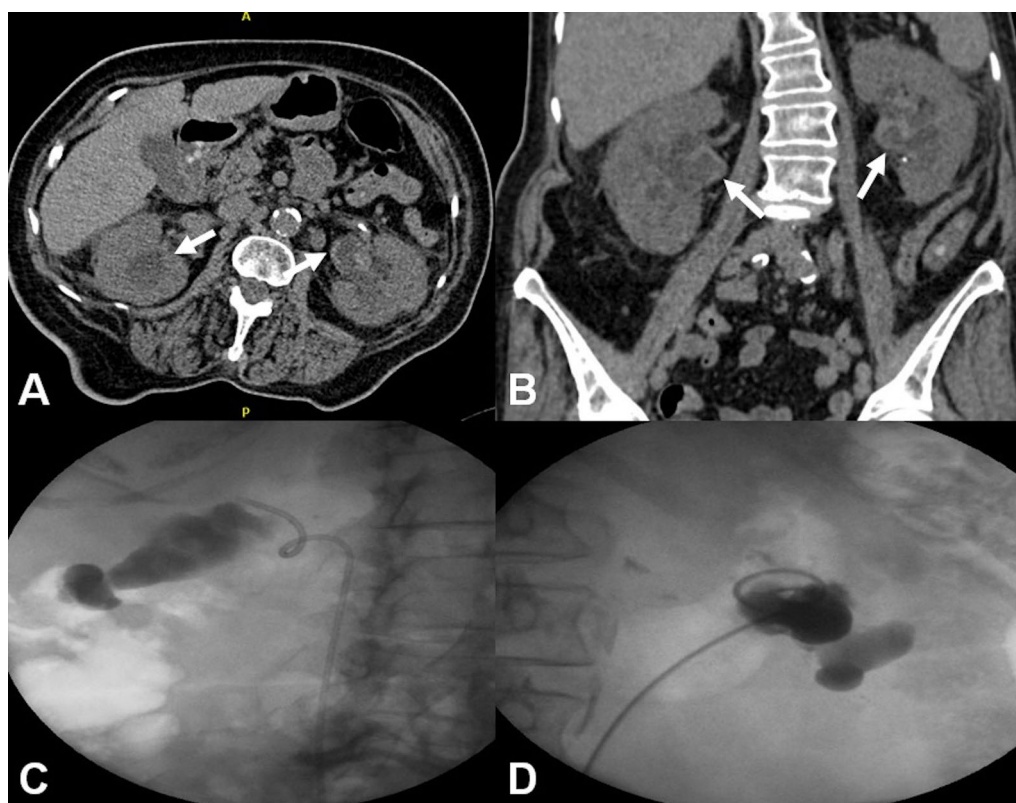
A Unenhanced computed tomography (CT) scan of the abdomen and pelvis, axial view, showing bilateral hydronephrosis with urothelial thickening of the renal pelvis (arrow) that may represent urothelial malignancy. B Coronal view of the unenhanced CT scan of abdomen and pelvis showing similar dilatation and thickening (arrow). C Fluoroscopic view of the retrograde pyelography, right side, showing no filling defects within the right renal pelvis suggestive of any malignancy, along with a right double J ureteral stent, seen in good position. D Left-sided fluoroscopic view of the retrograde pyelography showing as well no filling defects within the left renal pelvis suggestive of any malignancy, along with a left-sided double J stent, seen in good position
